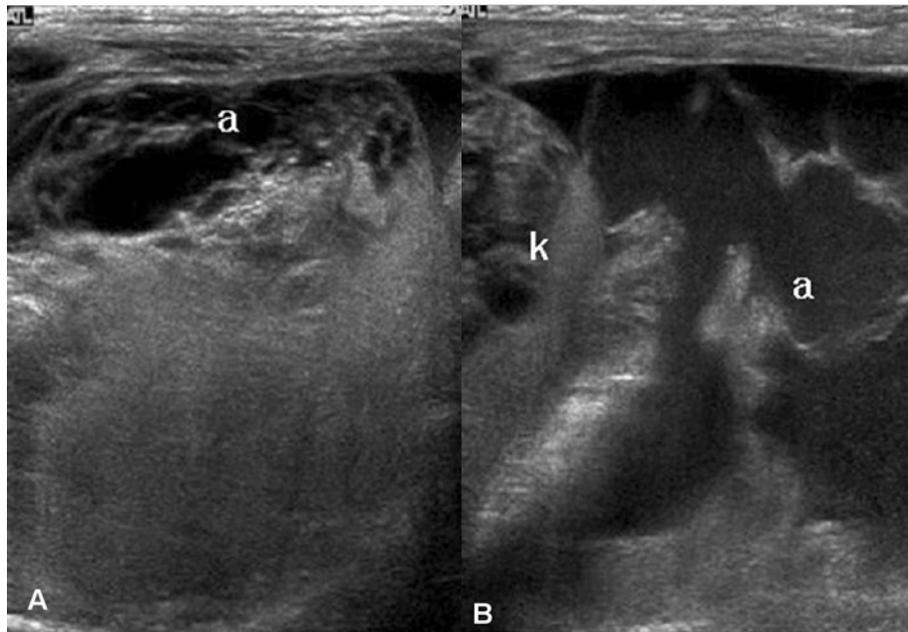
(A) Ultrasonography of the liver on day 7 of life demonstrates a hypoechoic, large amount of ascites (a) anterior to the left lobe with a multiseptal formation and (B) complicated ascites (a) inferior to the right kidney (k).
